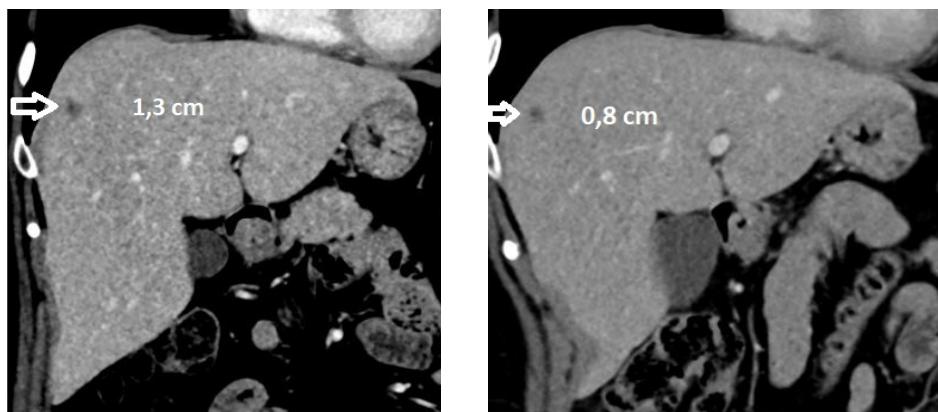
The patient received therapy with Vibramycin and Rifoldin, her symptoms consecutively diminished. On monthly CT control imaging the principal lesion measured 1.35cm (a) and 8mm in September 2020 (b), further controls by sonography could not detect it any more. Latest contact with our hospital was in July 2022, she had clinically completely resolved and laboratory parameters were negative for infection.
